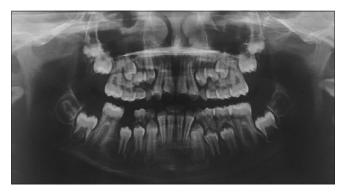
Postoperative orthopantomogram after 6 months shows satisfactory healing and erupting 45
